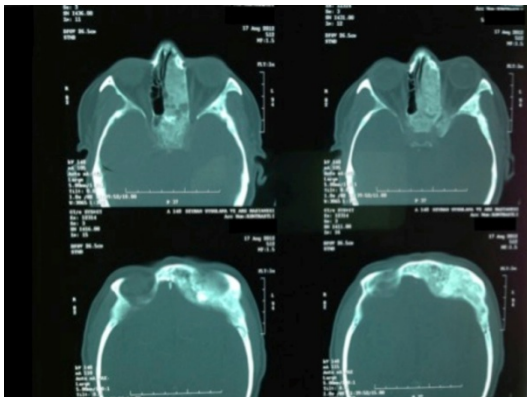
Computed tomography demonstrate the Obstruction of nasal airway by the enlarged middle turbinate
